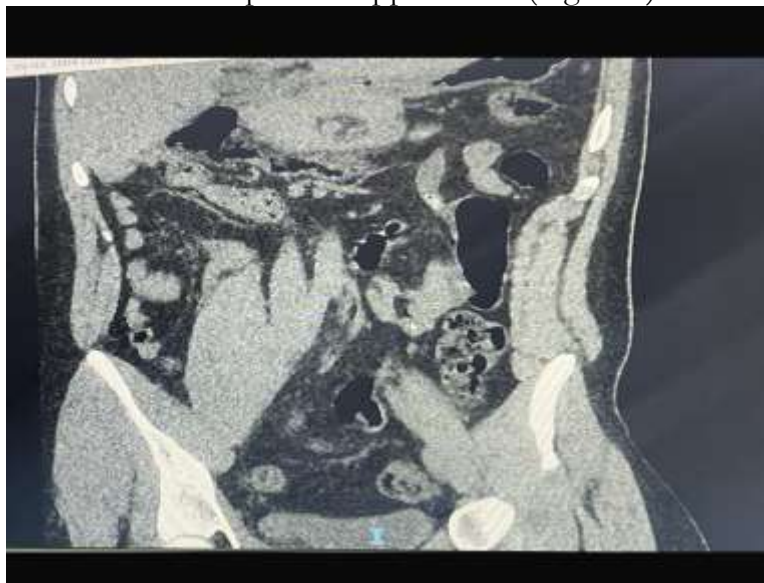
Coronal contrast-enhanced CT image demonstrating intestinal malrotation with left-sided small bowel and an inflamed appendix.
